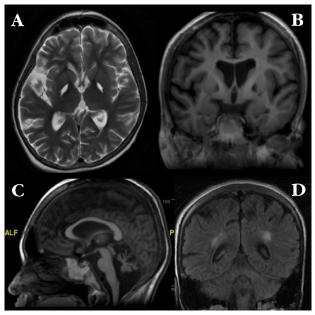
Axial T2-weighted brain MRI (A), showing striking hyperintensity in the pallidum bilaterally, with corresponding areas of hypointensity on T1 sequence (B). There is also prominent cerebral (B) and cerebellar atrophy (C) as well as hyperintensity in the posterior periventricular regions bilaterally on T2 FLAIR (D). There were no areas of abnormal signal on gradient-echo sequence (not shown).
